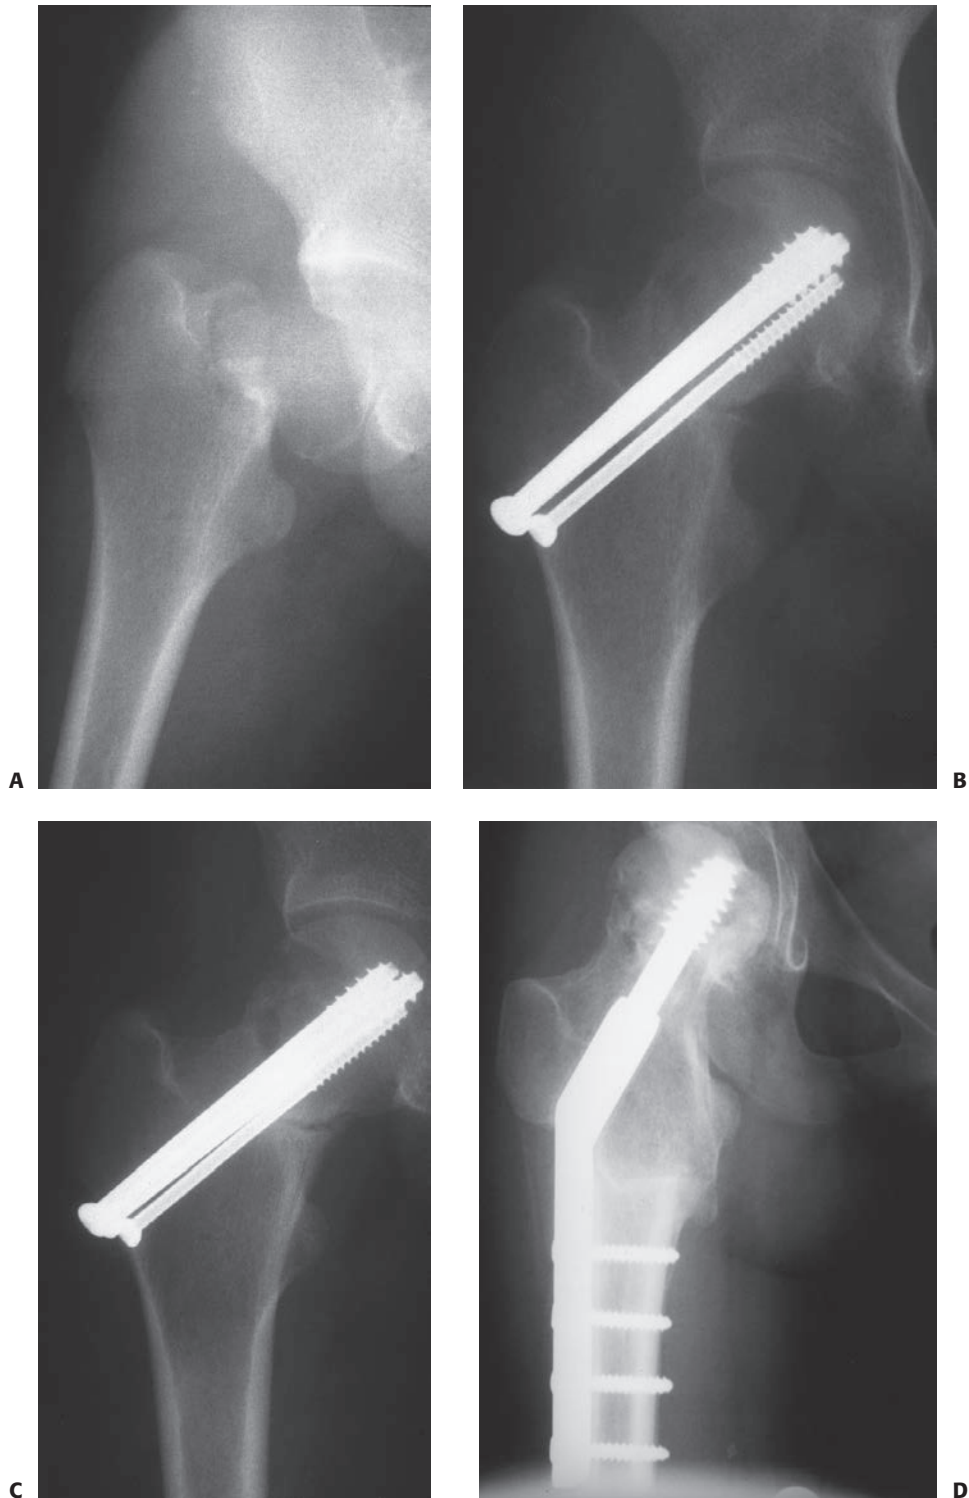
A: A 15-year-old girl with a markedly displaced type II femoral neck fracture. B: She underwent open reduction and internal fixation with two 7.3-mm cannulated screws and one 4.5-mm cannulated screw. Primary bone grafting of a large defect in the superior neck was also performed. C: Radiograph at 5 months showing a persistent fracture line. D: Six weeks after valgus intertrochanteric osteotomy. The fracture is healing.
